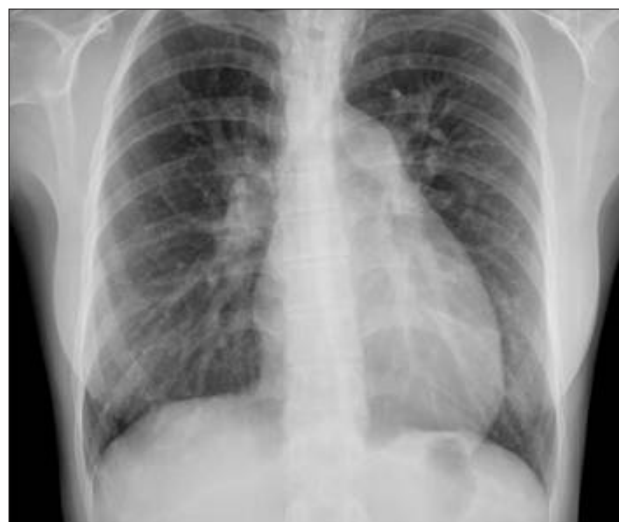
Chest X-ray showed mild cardiomegaly and increased pulmonary vascularity in both lungs.
